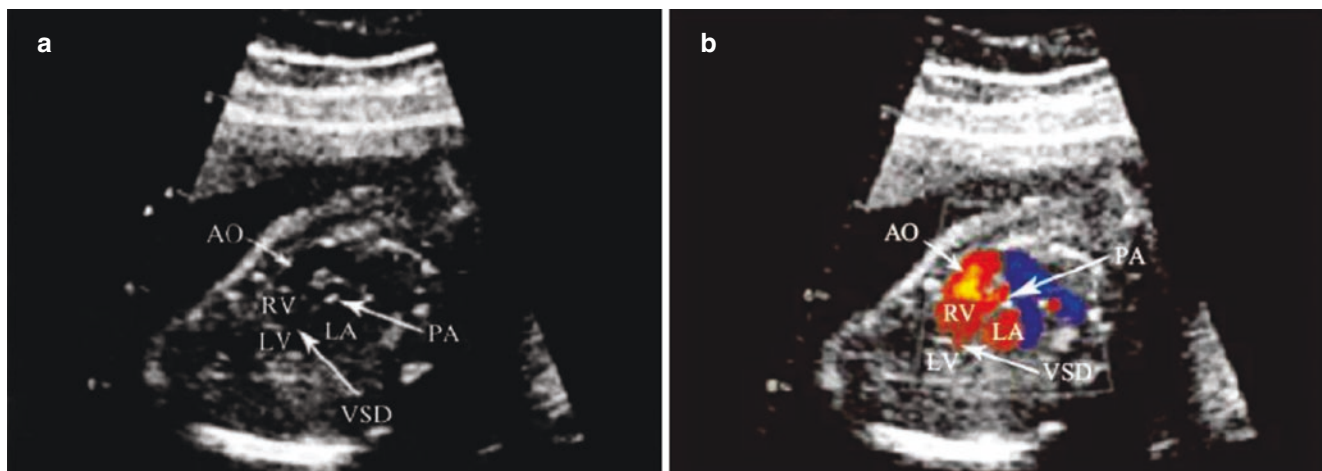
Double-outlet right ventricle. (a) A nonstandard view of fetal heart shows that the pulmonary artery and the aorta arise from the RV. (b) A nonstandard view of the fetal heart shows that the color Doppler flow imaging of the two major arteries arises from the RV
